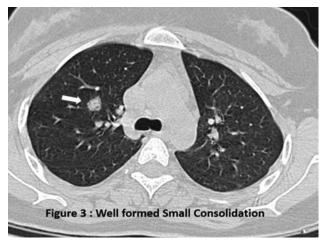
HRCT Axial image showing well formed consolidation
